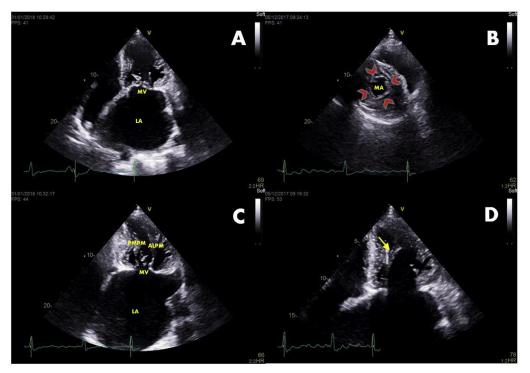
Transthoracic echocardiography, apical four-chamber view (A), showing aneurysmal LA dilatation, concentric severe left ventricular hypertrophy, and a deformed MV with elongated leaflets; subcostal view (B), showing quadrangular mitral annular geometry (*red arrowhead*); apical two-chamber view (C), showing apical insertion of papillary muscles; and apical four-chamber view (D), showing accessory papillary muscle (*arrow*), originating in the apical lateral region of the left ventricle. *ALPM*, Anterolateral papillary muscle; *LA*, left atrium; *MA*, mitral annulus; *PMPM*, posteromedial papillary muscle.
